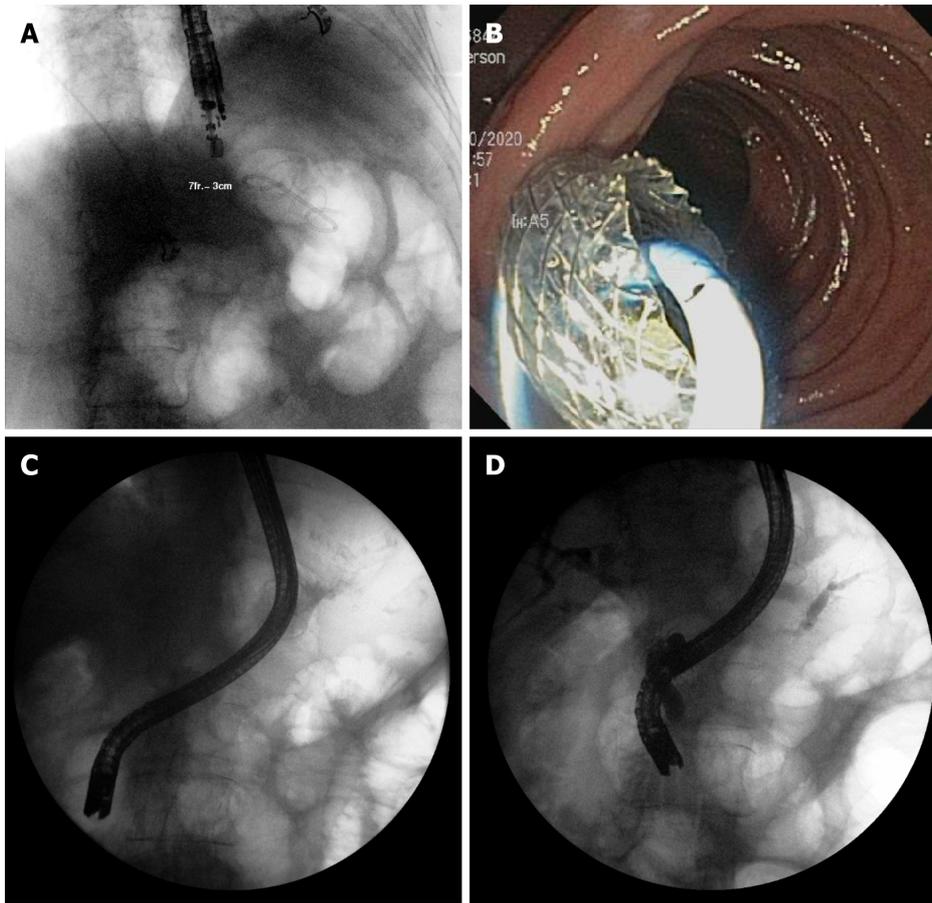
Endoscopic ultrasonography-directed transgastric endoscopic retrograde cholangiopancreatography. A: Endoscopic ultrasonography placement of lumen apposing metal stents (LAMS) gastrogastroic fistula; B: Endoscopic view of LAMS; C: Duodenoscope passing through LAMS for endoscopic retrograde cholangiopancreatography; D: Successful cholangiogram and pancreatogram.
